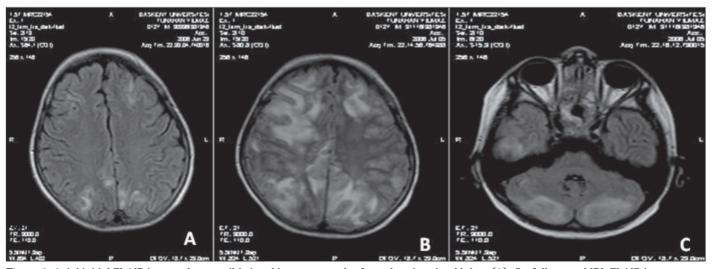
Axial initial FLAIR image shows mild signal increase on the frontal and parietal lobes (A). On follow-up MRI, FLAIR images show severe progression of the lesions on bilateral frontal, parietal and temporal lobes and new lesions are seen on bilateral cerebellar hemispheres (B,C)
